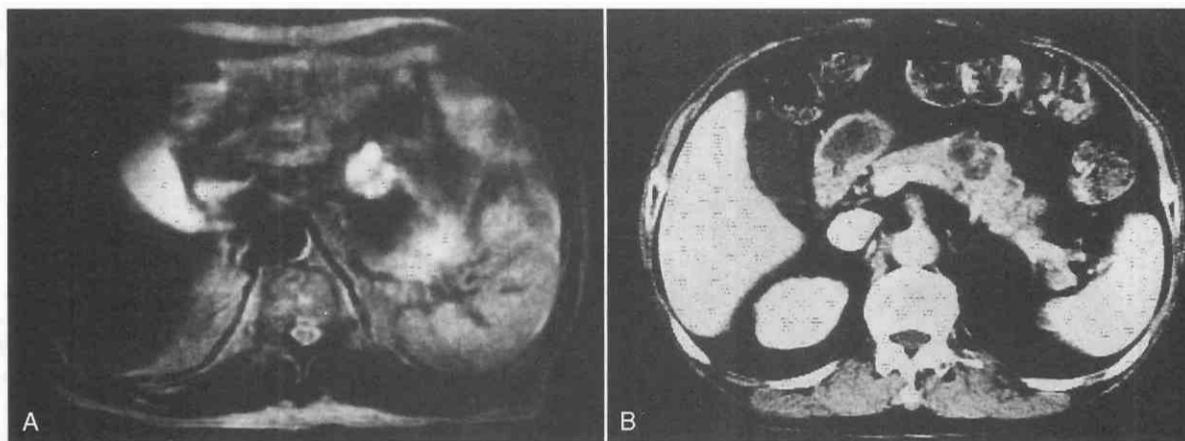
Microcystic adenoma in the body of the pancreas. *A*, T2-weighted MR image (SE, TR = 2000 msec, TE = 75 msec) shows a hyperintense tumor that appears inhomogeneous in intensity owing to the low intensity of a central scar. *B*, Enhanced CT scan shows a lobulated tumor with a calcified central stellate scar. (From Minami M, Itai Y, Ohtomo K, et al: Cystic neoplasms of the pancreas: Comparison of MR imaging with CT. *Radiology* 171:53-56, 1989.)
